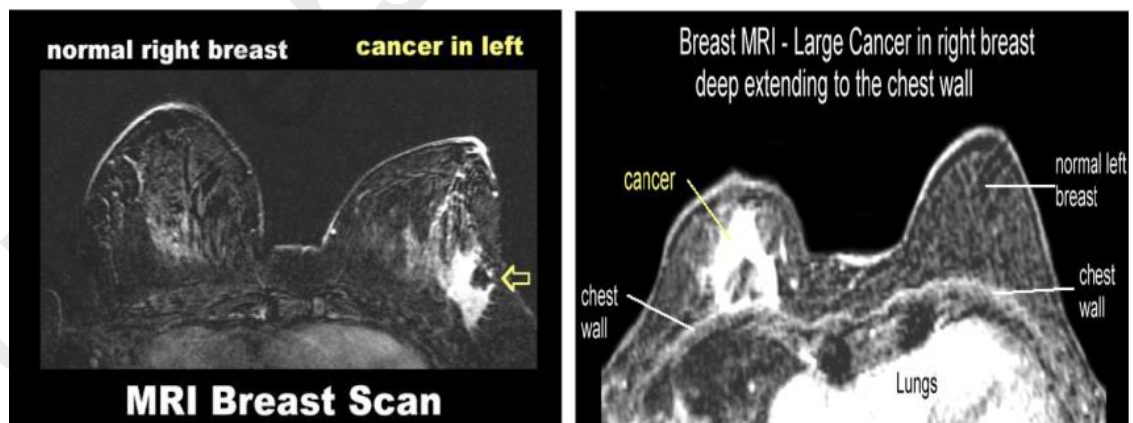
Breast MRI image samples
